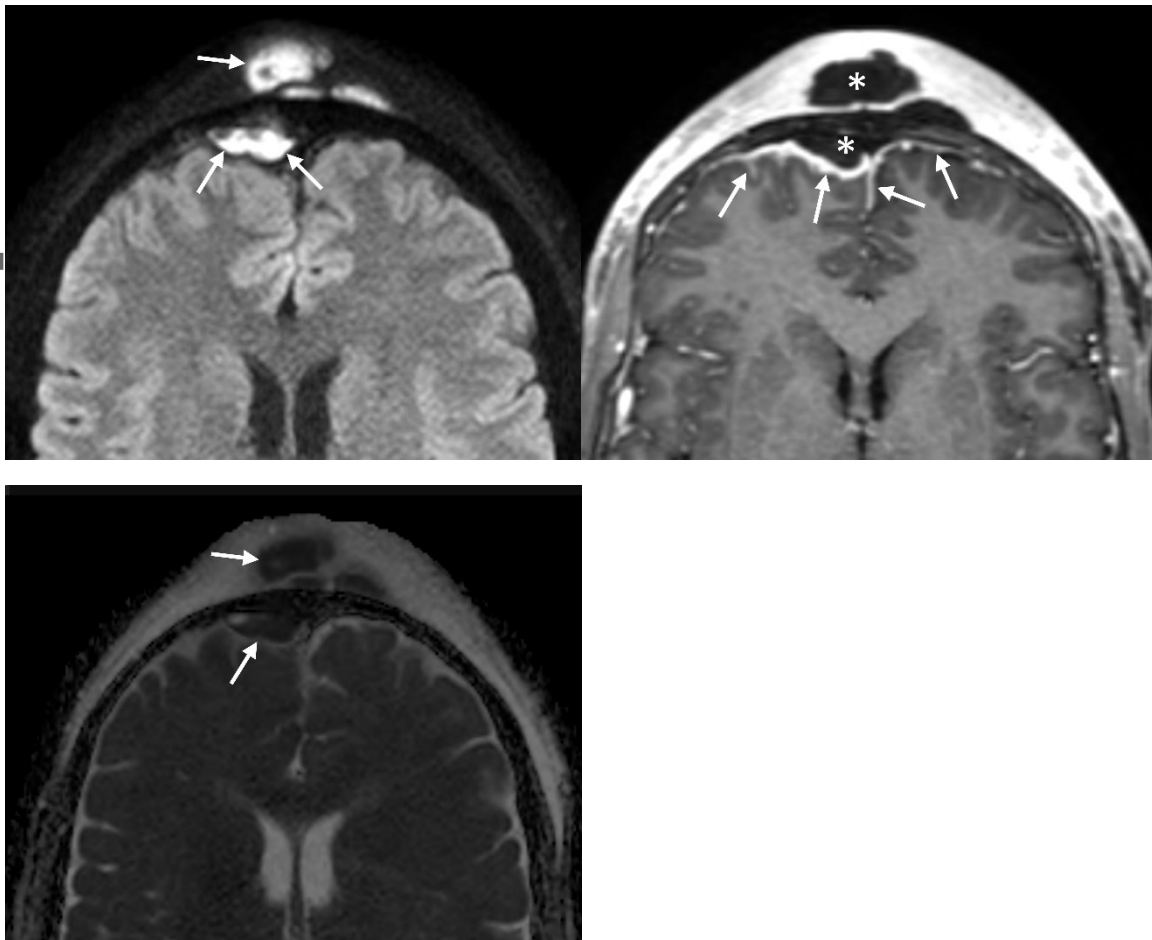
24-year-old male with intracranial subdural empyema and meningitis associated with frontal sinusitis. Contrast-enhanced fat-suppressed T1-weighted image (A) shows intracranial subdural and frontal subcutaneous areas of poor enhancement (*) with enhancement at the margins, indicating an abscess. Meningeal thickening (arrows) with enhancement adjacent to the intracranial abscess suggests meningitis. Diffusion-weighted imaging (B) shows high signal intensities (arrows) with the low mean apparent diffusion coefficient value of $0.51 \times 10^{-3} \text{mm}^2/\text{s}$ (C, arrows), indicating diffusion restriction, consistent with intracranial subdural empyema and frontal subcutaneous abscess (Pott's puffy tumor).
